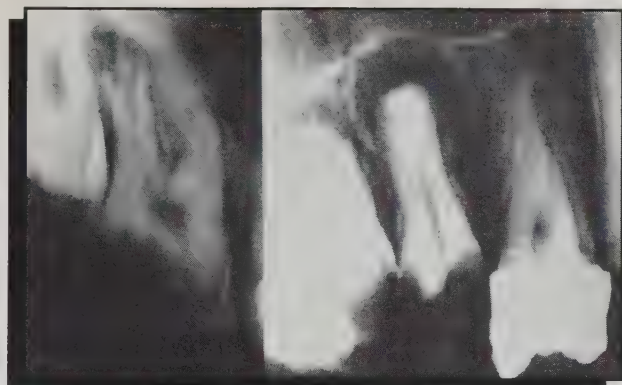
This radiographic image has been manipulated to enhance its density and contrast.
